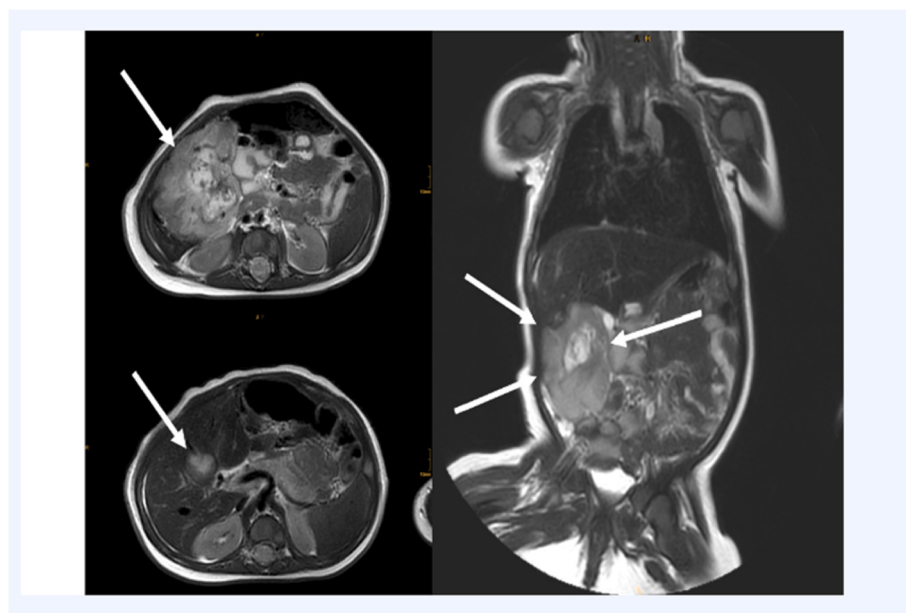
Radiologic findings (MRI) of an 11.5 cm measuring HVMCP (arrows) in liver segments I/IV of a 2-month-old girl (case 1).
